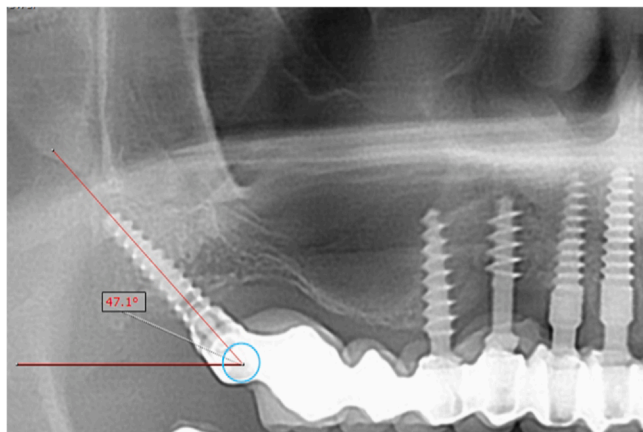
Implant angulation of insertion relative to Frankfort plane of anteroposterior axis on panoramic radiograph measured postoperatively.
